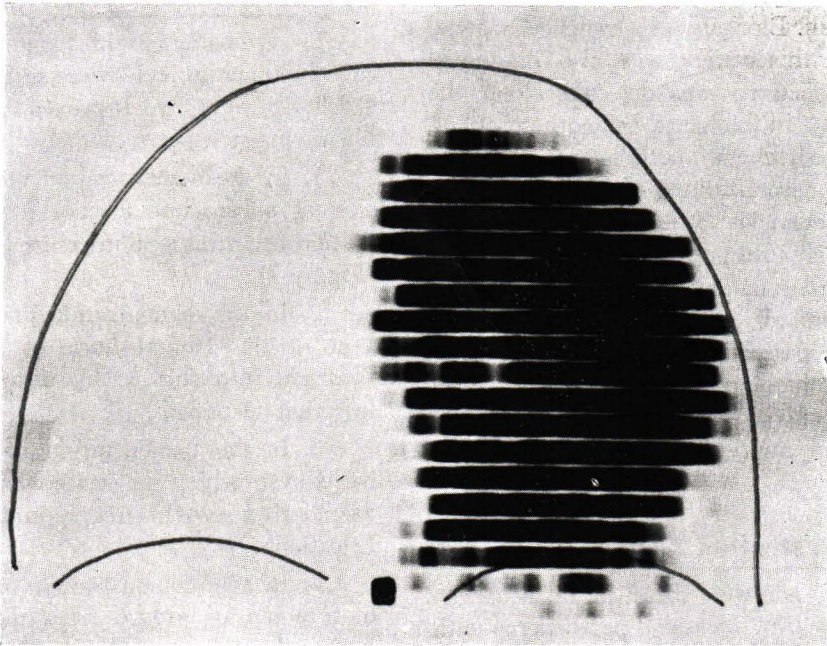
Antero - posterior scintigram after intraventricular injection of ^{131}I - RISA showing hydrocephalus with obstruction at the foramen of Monro. No radioactivity was detected over the opposite lateral and third ventricles.
